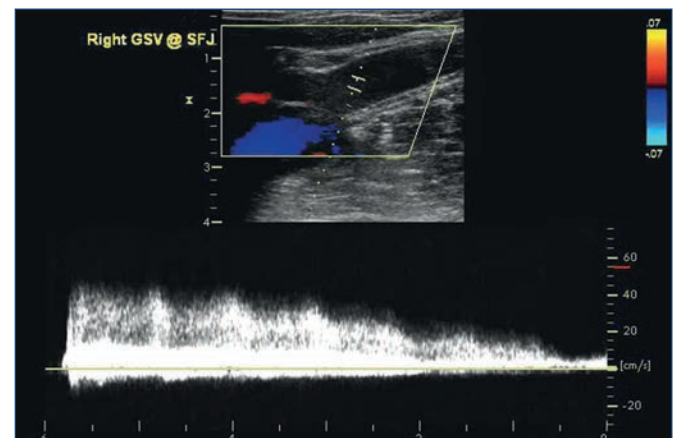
Longitudinal ultrasound image demonstrating six seconds of high volume reflux at the proximal saphenofemoral junction of the great saphenous vein.
